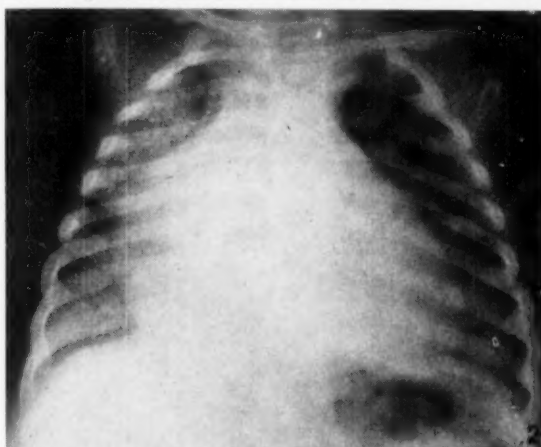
X-ray of chest showing marked right atrial and ventricular enlargement.
